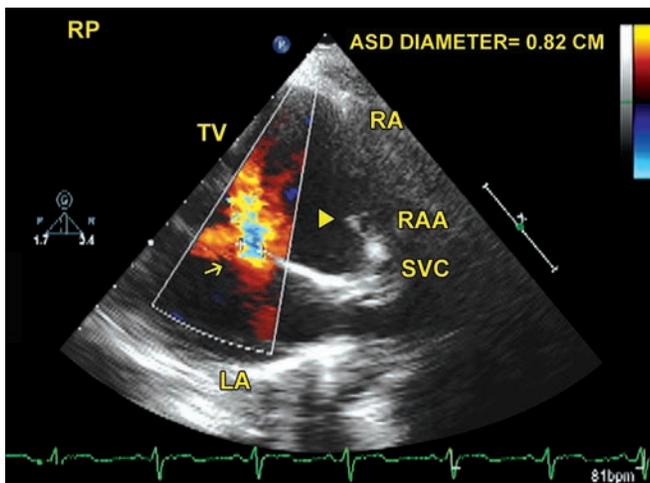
Right parasternal (RP) examination. The arrow shows flow signals moving from the LA into the RA indicative of a PFO/secondum atrial septal defect (ASD). Arrowhead points to crista terminalis.
